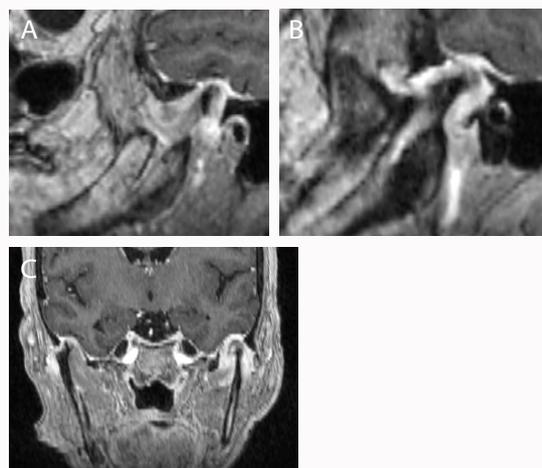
MRI of the brain with intravenous contrast. A) Oblique sagittal view of the right condylar head. B) Oblique sagittal view of the left condylar head. C: Coronal view of the bilateral condylar heads.
